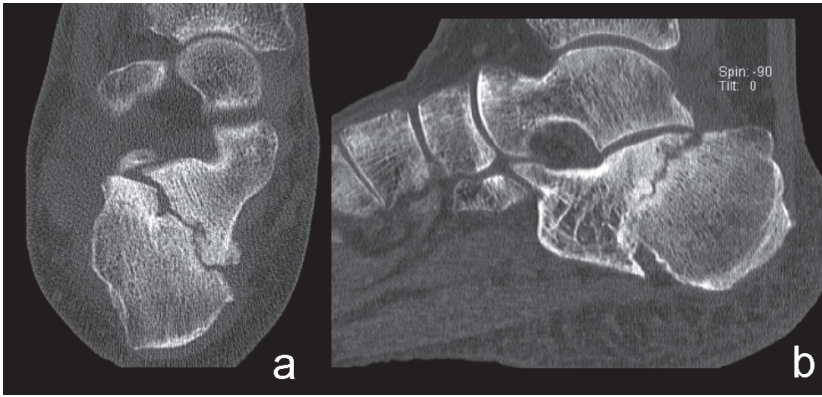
a, Case 2: Semi-coronal CT-scan image 5 months after conservative treatment showing delayed union; b, Sagittal view.
